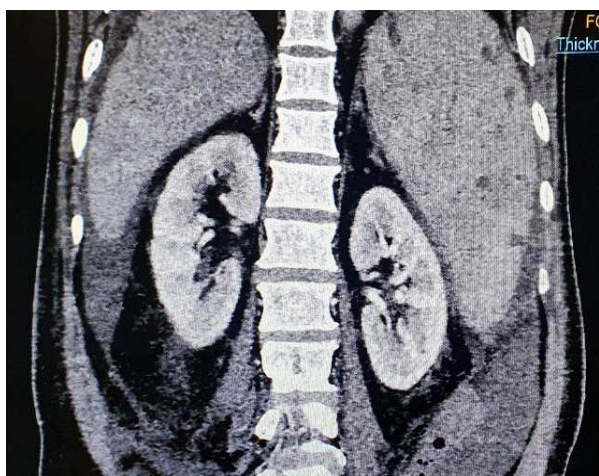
Computed tomography abdomen showed multiple well defined, hypodense regions within the spleen.
